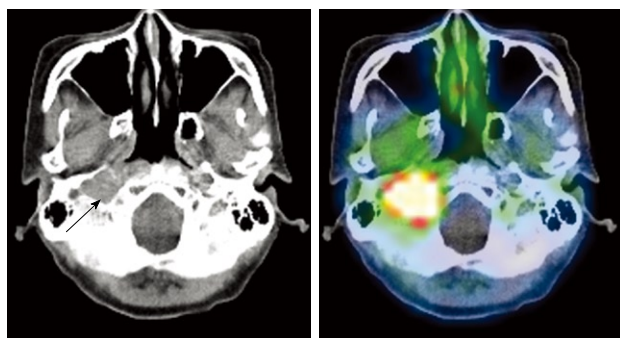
Malignant paraganglioma at the right jugular foramen. Axial CT and PET/CT of the base of skull. Soft tissue mass in the right jugular foramen showing intense tracer avidity, compatible with a somatostatin receptor expressing tumor.
